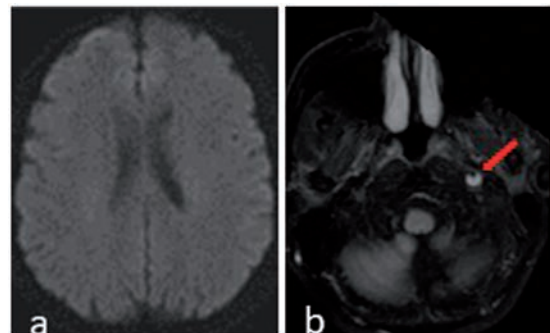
(a) Diffusion weighted MRI sequence of the patient showing no acute cerebral infarction. (b) On FLAIR sequence is demonstrated left high signal crescent sign of left extra-cranial carotid artery (red arrow).
